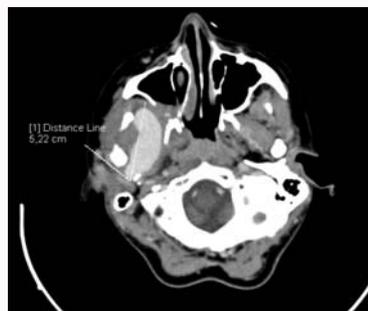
CT scan with contrast showing showed a liquid mass of 5.2 cm × 2.7 cm × 4.7 cm with a strong hyperdense aspect after contrast administration around the right ramus.
